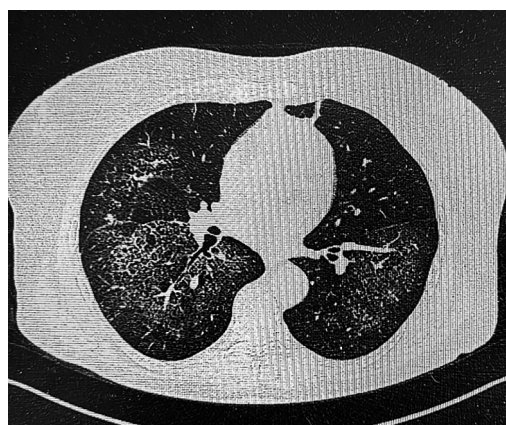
Thoracic computed tomography image of bilateral crazy paving mainly in the middle lobe
